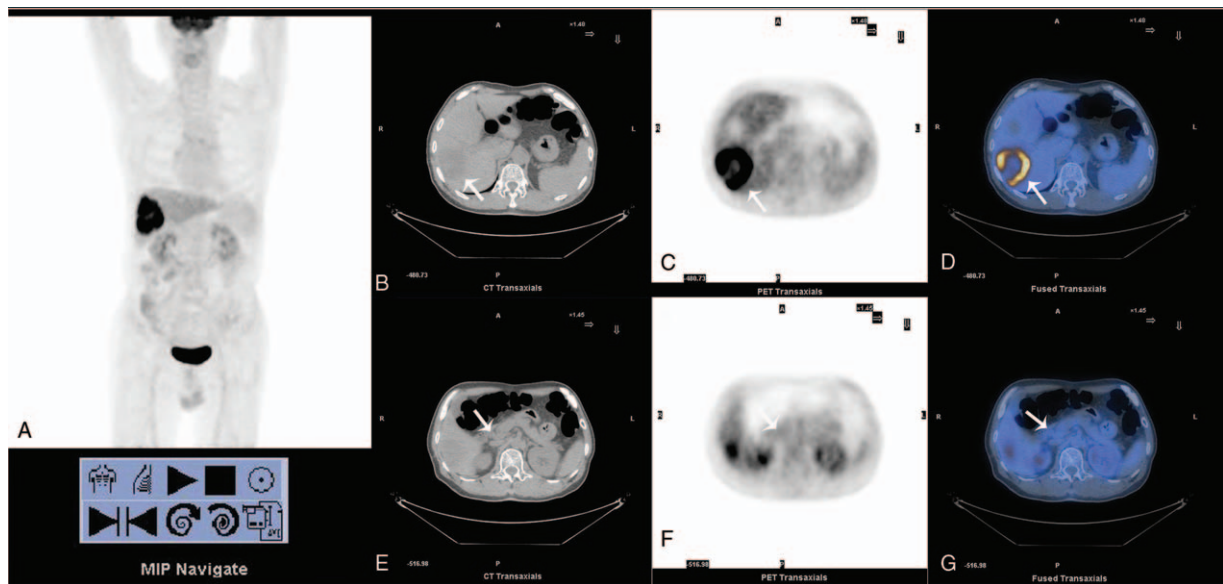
^{18}F -FDG PET/CT scanning demonstrated a low density lesion in the right lobe of liver, the maximum cross section was approximately 50.8×39.8 mm and the SUVmax was about 17.8. The maximum cross section and the SUVmax of the largest lymph node in the hepatic hilum were about 13.2×9.8 mm and 1.8. The lesion in right lobe of liver (white arrow): the maximum intensity projection PET image (A), transverse CT (B), and corresponding PET (C), and fusion images (D). The largest lymph node in the hepatic hilum (white arrow): transverse CT (E), and corresponding PET (F), and fusion images (G).
